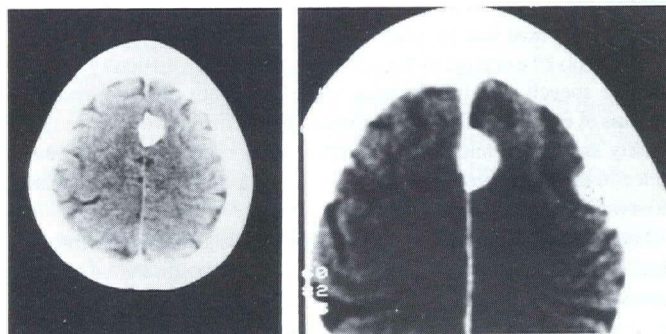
Case 2: Presurgical computed tomography scans. (Enhanced view, right panel.)
